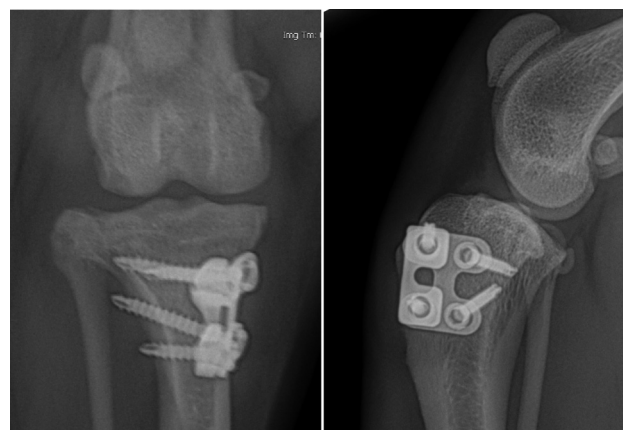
Craniocaudal and mediolateral radiographs taken 7 months after surgery, immediately before implant removal, in a French bulldog weighing 9.2 kg with intermittent skipping lameness. The osteotomy has healed, the implants are in the correct position, and no implant-related complications were noted. There is mild cranial displacement of the fat pad, indicative of mild joint effusion.
